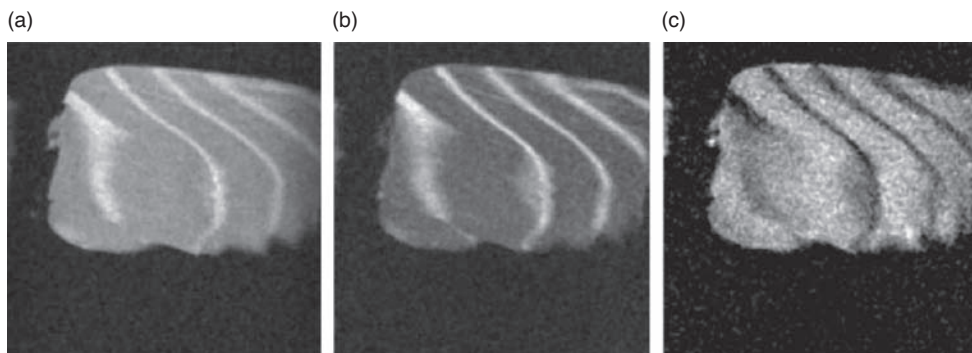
Proton density (a), fat (b), and water (c) MR images of salmon fillet. In the proton density image, protons from both water and fat are visible, whereas in fat (b) and water (c) images, only protons from fat and water are detected, respectively. Adapted from Veliyulin *et al.* [5], with kind permission of Springer Science and Business Media.
